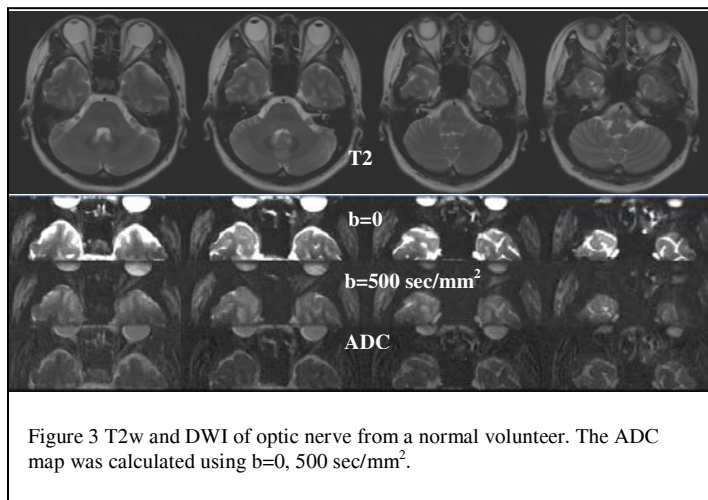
T2w and DWI of optic nerve from a normal volunteer. The ADC map was calculated using $b=0$, 500 sec/mm².
